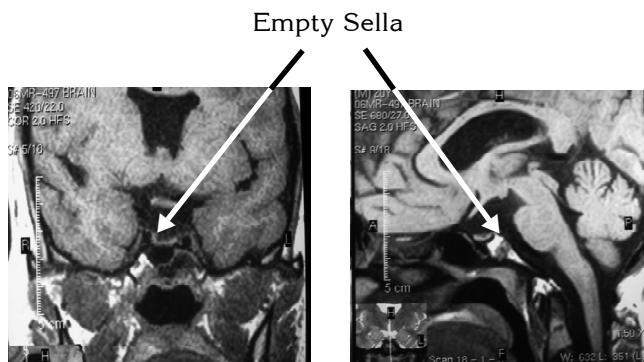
Cranial MRI (A, Coronal Cut; B, Sagittal Cut). The Arrows Point to the Fluid-Filled Sella.
